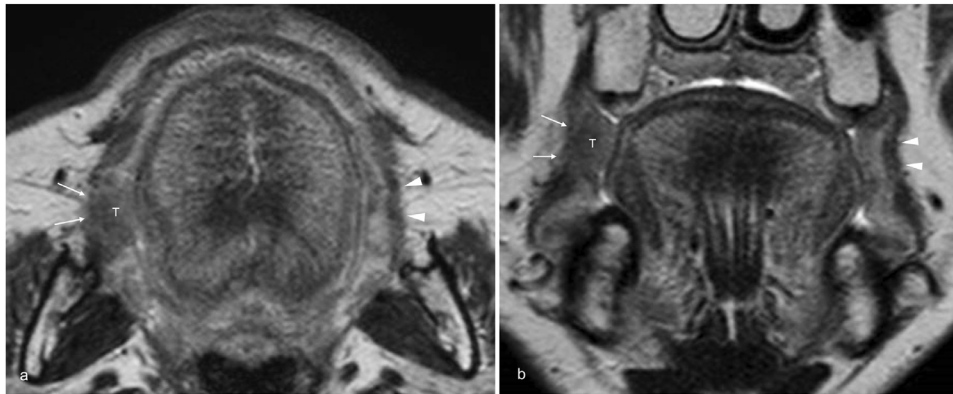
Magnetic resonance imaging findings of buccinator muscle invasion. A 76-year-old male with squamous cell carcinoma of the right buccal mucosa. (a) Axial and (b) coronal T2-weighted images reveal squamous cell carcinoma of the buccal mucosa (T) with invasion into the right buccinator muscle (arrows). The left buccinator muscle (arrowheads) is normal.
